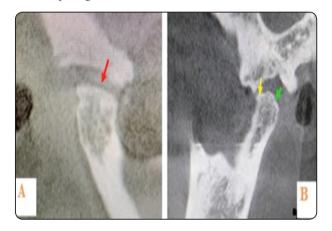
A CBCT at 12 months PO showing flattening of the condyle (red arrow), B shows CBCT at 24 months PO showing osteophytic changes (yellow arrow and bone erosion green arrow)
